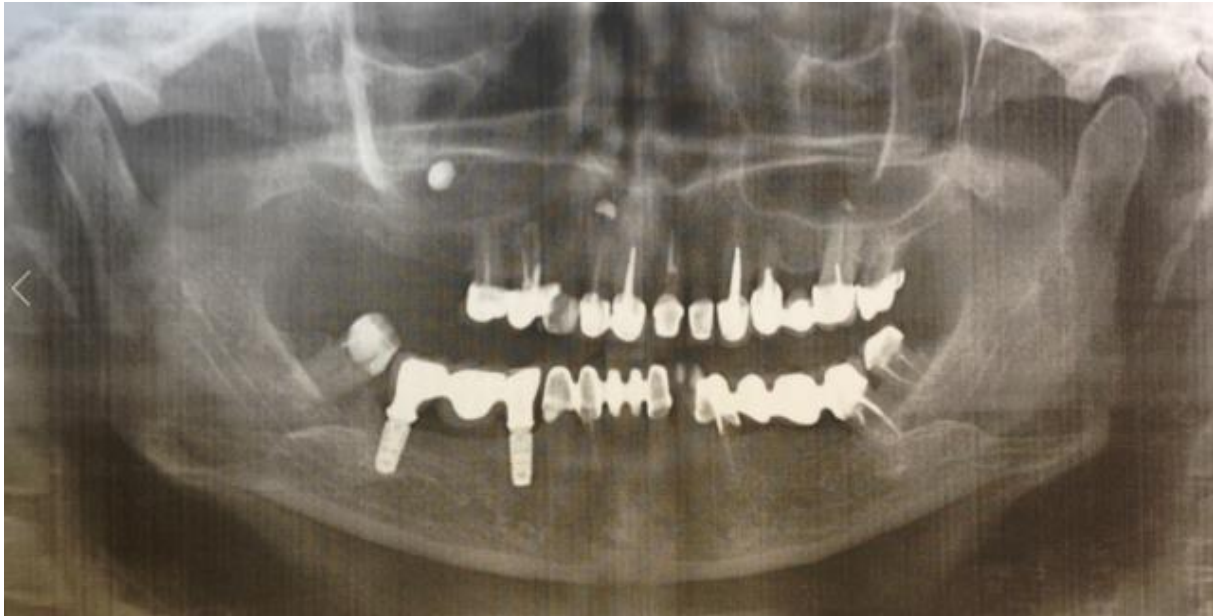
X-ray made before surgical treatment.
